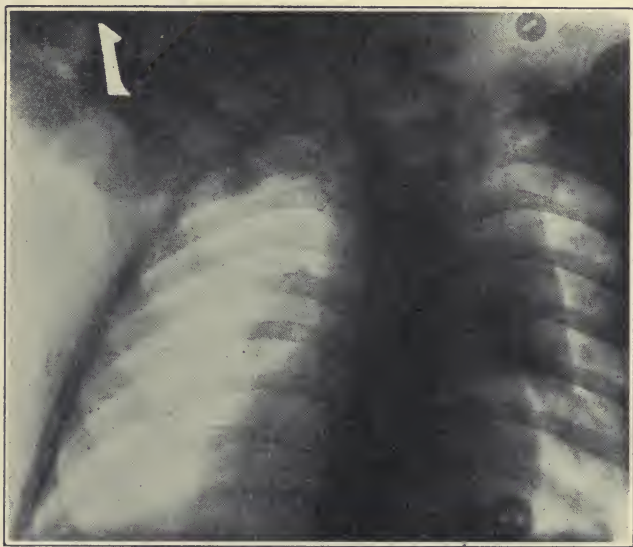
Roentgenogram made Aug. 5, 1919, showing decided shadow in thymic region, especially on right side. Note sharp, angular projection at right lower end of shadow.
